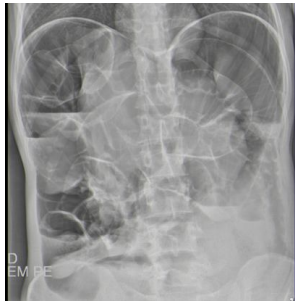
Abdominal X-ray in orthostatism
